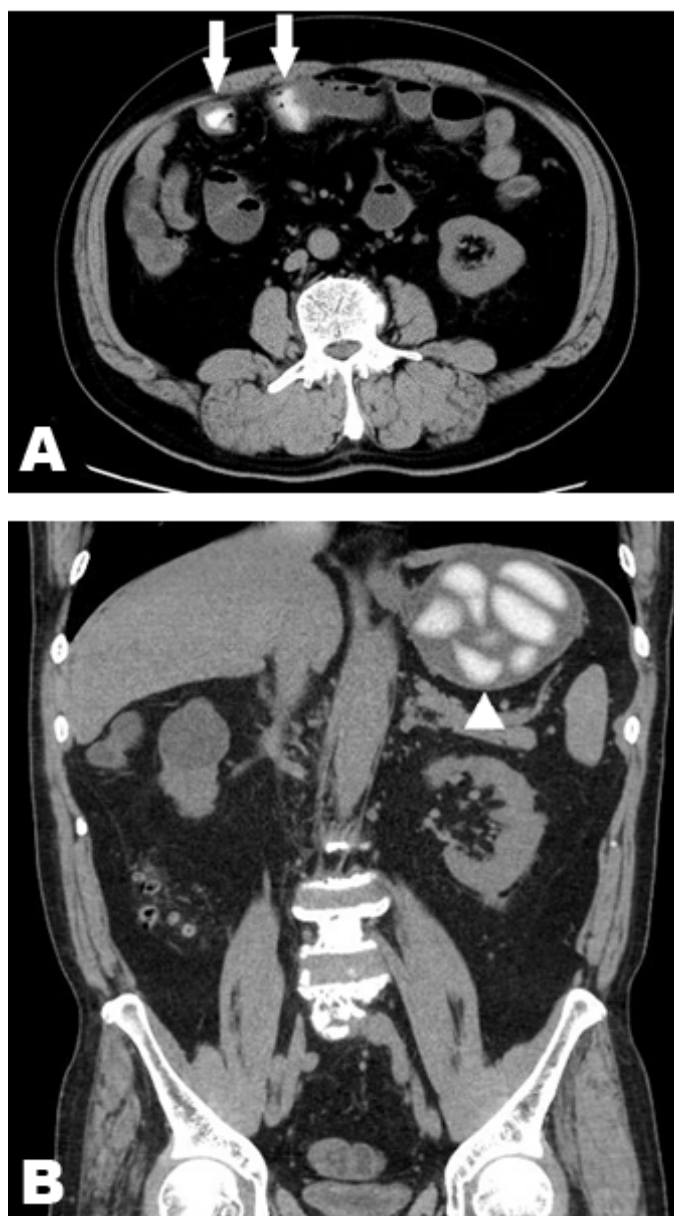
(A, B) Computed tomography scan of axial and coronal views revealing high density materials in the stomach (arrow head) and in the small intestine (arrows) with proximal intestinal dilation.
